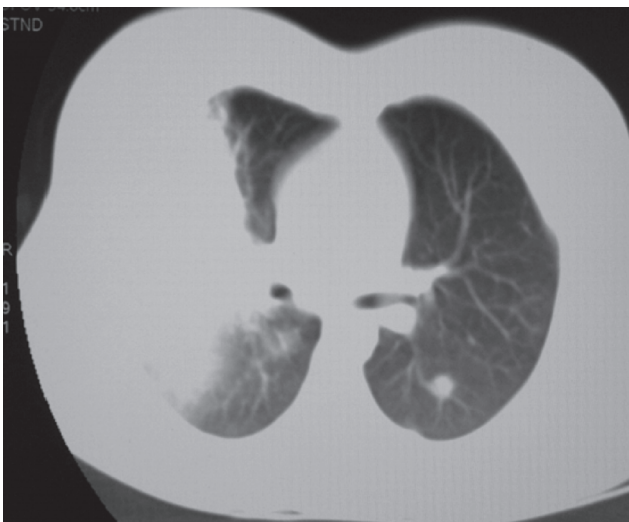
HRCT thorax showing consolidation in the right upper lobe with cavitation and multiple centrilobular nodules in the right upper and left lower lobes.
